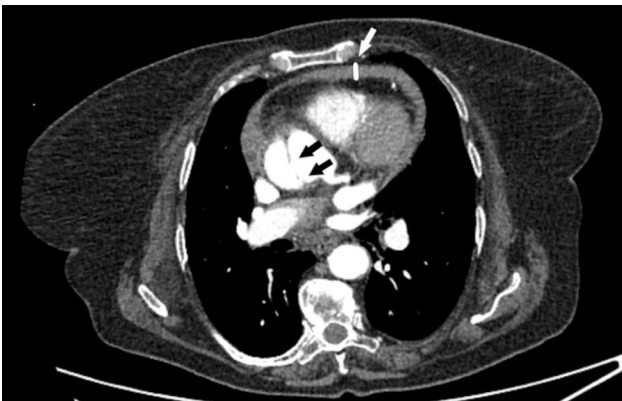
Contrast-enhanced CT scan of the thoracic vasculature in the transverse projection: intimal delamination within the lumen of the ascending aorta (black arrows) and accumulation of fluid in the pericardial sac (white arrow)
